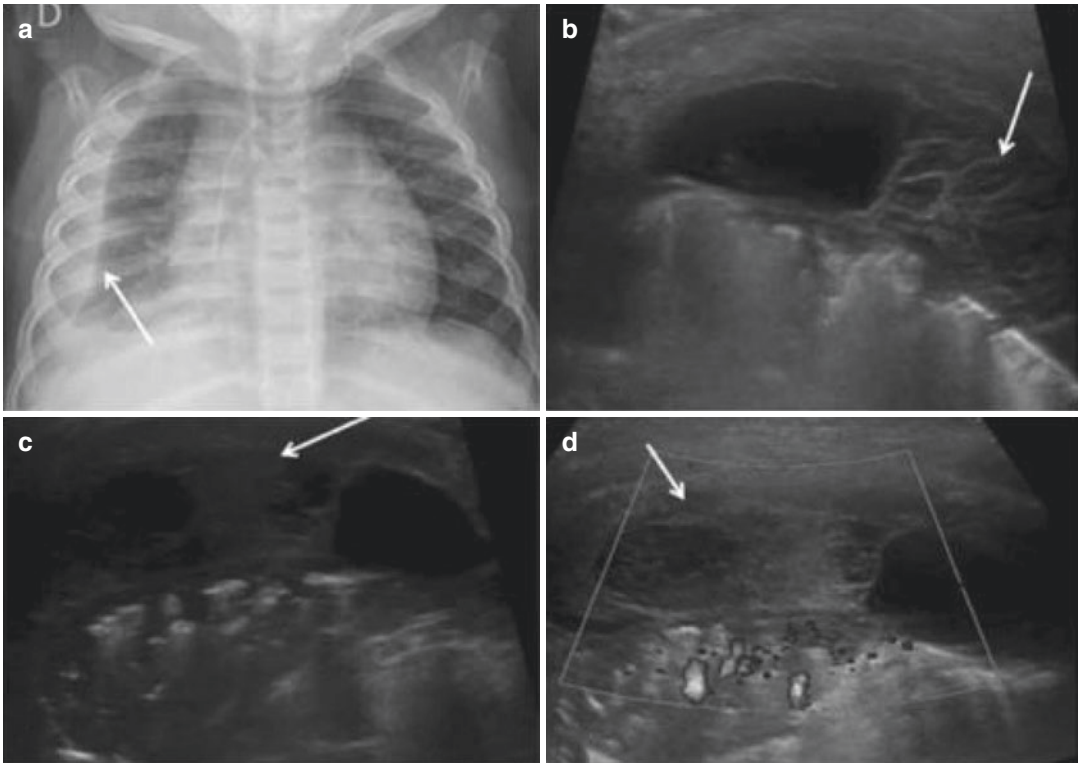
Right-sided pneumonia with parapneumonic pleural effusions and empyema in a 10-month-old infant. A chest x-ray (a) shows right pleural effusion (*arrow*).
